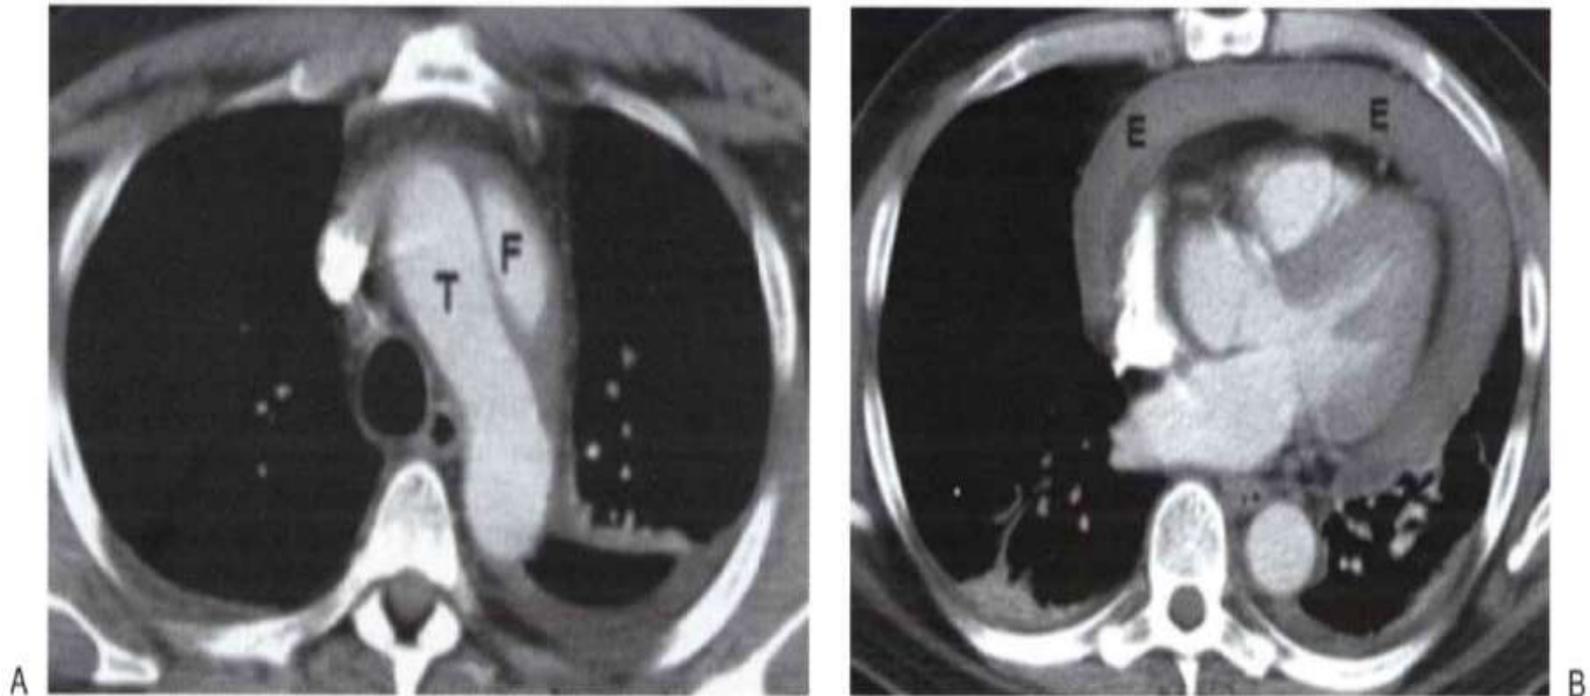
Aortic dissection. A: CT scan shows two aortic lumina—a false lumen (*F*) and a true lumen (*T*)—separated by an intimal flap. B: CT scan at a more inferior level shows a pericardial effusion (*E*) that is of high attenuation, indicating hemorrhage.
